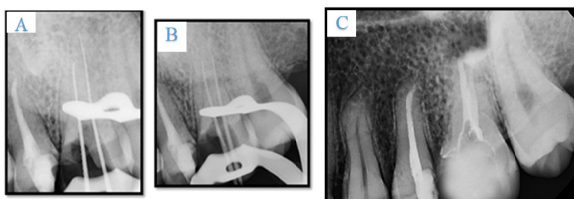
A) Working length determination; B) Master cone determination C) Post-operative radiograph after treatment
